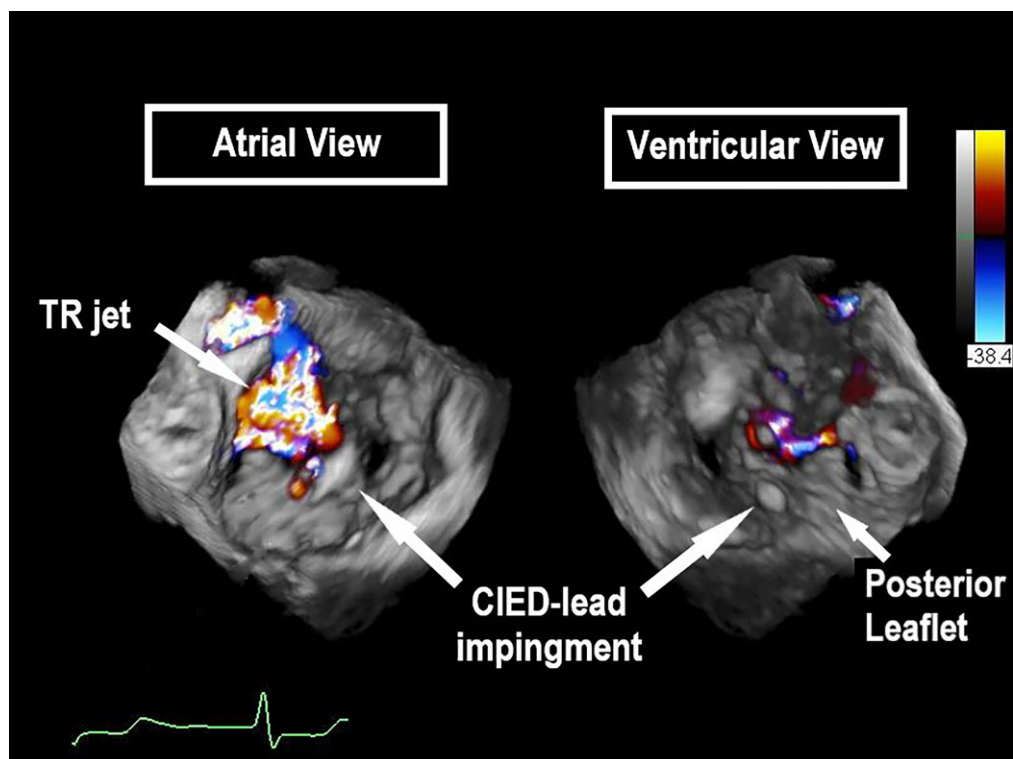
Three-dimensional transoesophageal echocardiogram showing cardiac implantable electronic device-lead impingement of tricuspid valve posterior leaflet.
